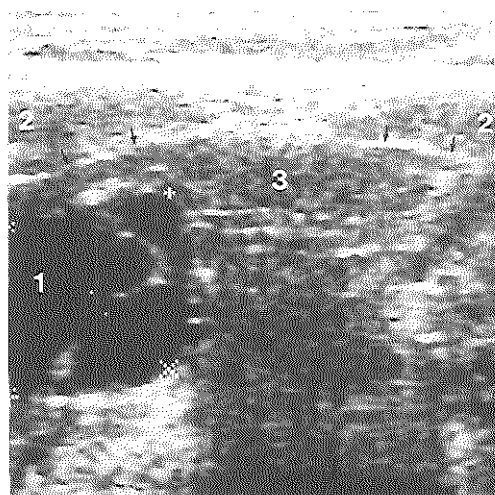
Transverse ultrasound view of the floor of the mouth. A simple ranula (1) is located at the oral side of the mylohyoid muscle (arrows). The relationship to the digastric (2) and genioglossal muscles (3) is shown.
